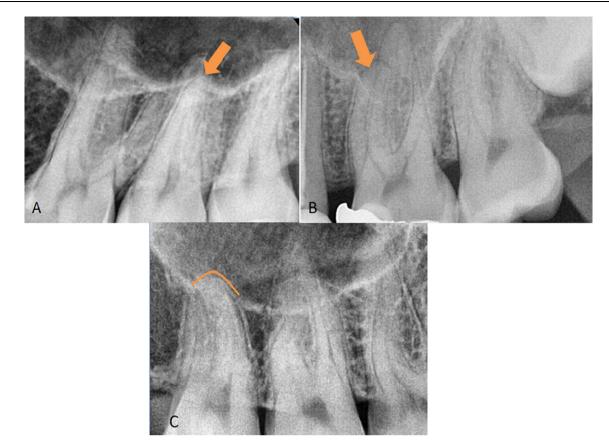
Digital periapical images showing: A = Interruption of the MSF, B = Discontinuity of lamina dura and C = Upward bending of the MSF to envelop the root.
